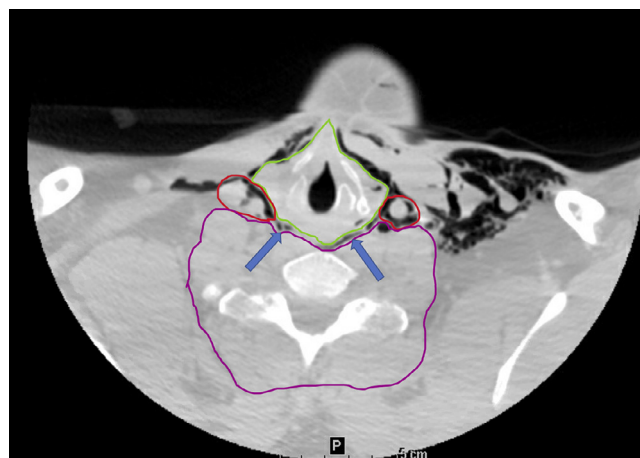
Axial view from the computed tomography (CT) neck scan without contrast at the level of the infrahyoid neck. Extensive air emphysema outlines several compartments of the neck. The bilateral carotid spaces (*red*), visceral compartment of the neck (*green*), and prevertebral compartment (*purple*) are well defined. There is also air emphysema between the prevertebral and visceral compartments in the retropharyngeal and danger space (*blue arrows*).
